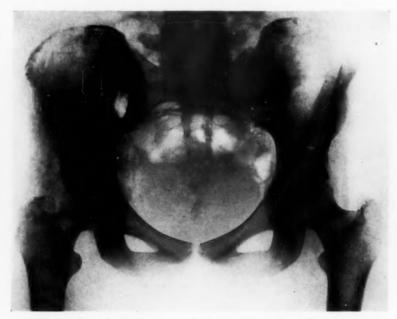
(Case 3.) Roentgenogram showing operative window through the sacroiliac joint, and early destruction of the hip joint. This hip joint became infected through the iliopectineal bursa.
